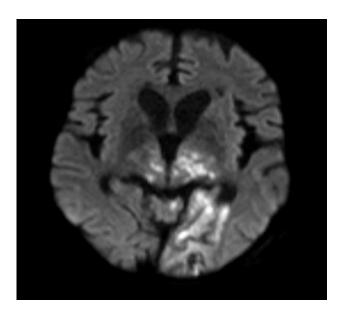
MRI brain of have ill defined areas of diffusion restriction in bilateral thalami, midbrain, pons, left occipital lobe.
